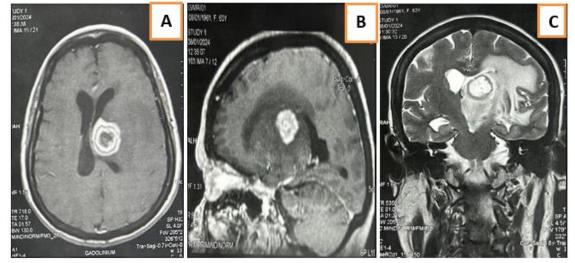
Cerebral MRI showing an intra-axial deep white matter process, oval and well-defined with regular contours (A+B), T2 iso signal (C), necrotic center enhanced peripherally after Gadolinium injection (A), associated with peri-lesional glove finger edema, exerting a mass effect (A); (A) Axial T1 section (Sat Fat) with Gadolinium injection; (B) T1 sagittal section (Sat Fat) with Gadolinium injection; (C) Frontal T2 section
